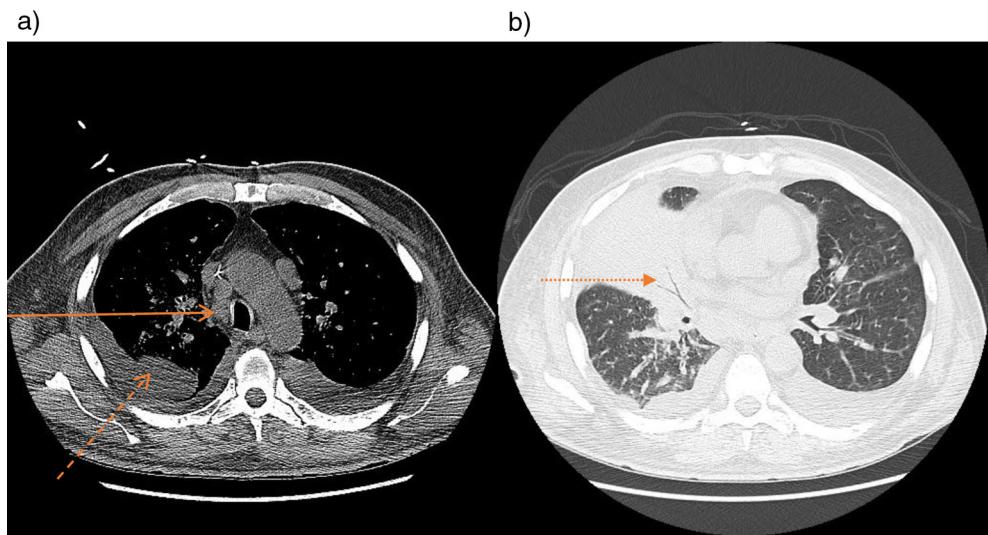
(a) Represents a non-contrast CT scan (mediastinal window) with arrow showing paratracheal lymphadenopathy and (dashed arrow) showing R sided pleural effusion. (b) CT scan showing R sided opacification with concern for pneumonia vs. post bronchial obstruction and concern for malignancy (this was the lesion that was biopsied).
